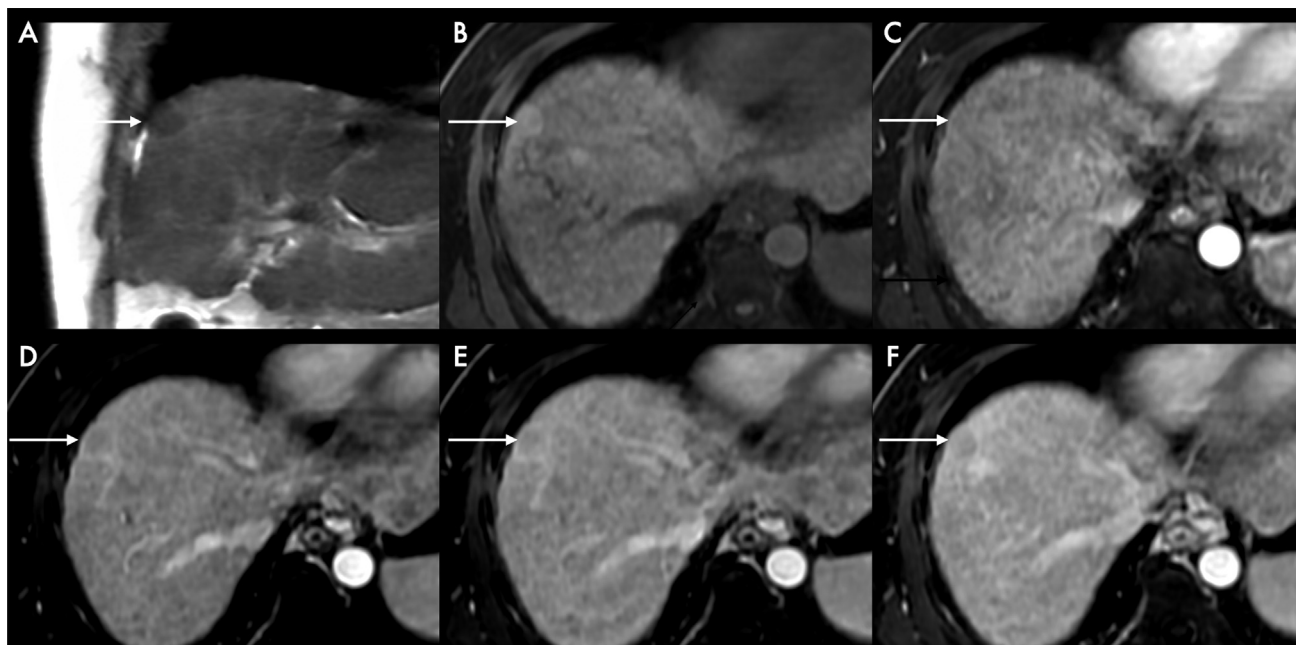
(A–F) LR-2 observation: A 8 mm focal observation (white arrow) is seen in the subcapsular location of segment VIII, appearing hypointense on single short fast spin echo coronal images and mildly hyperintense on precontrast T1-weighted images. Observation shows no definitive enhancement on dynamic postcontrast images.
